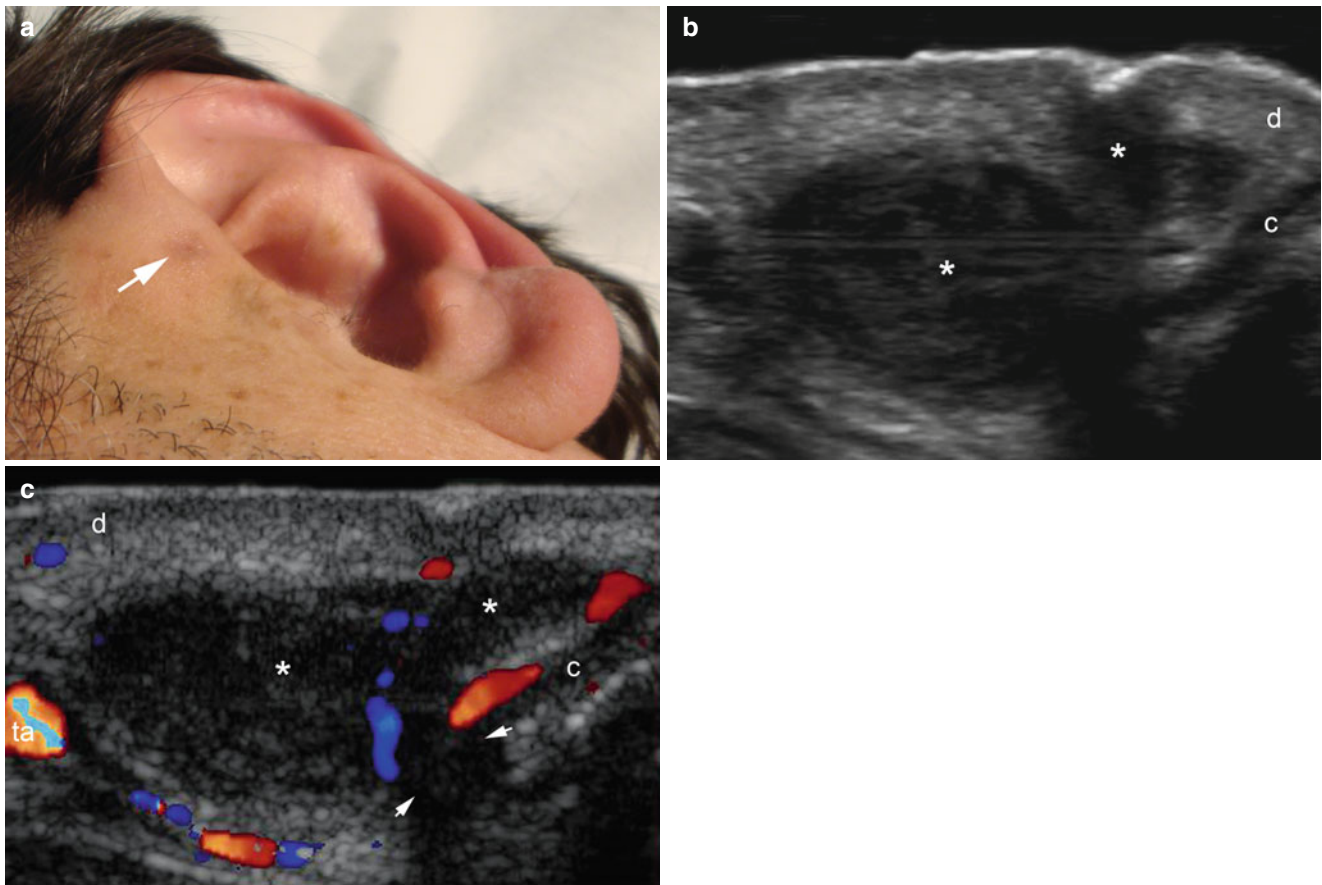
(a–c) Dilated preauricular sinus. (a) Clinical image shows a small pit in the left pre-auricular region. (b) Ultrasound image (gray scale, transverse view) demonstrates dilated hypoechoic sinus tract (*) attached to the anterior aspect of the cartilage. (c) Color Doppler
